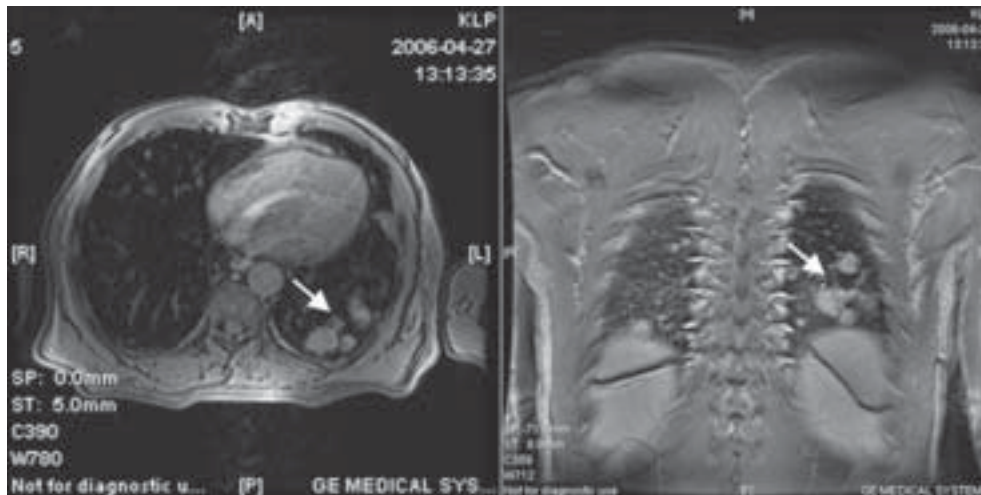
Chest MRI from 2006, before ^{131}I treatment. Lung metastases
